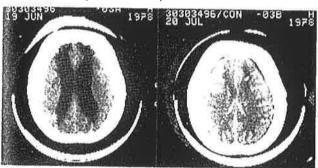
CT scan of the brain before and after the insertion of a ventriculoperitoneal shunt. Note the thick calvarium and the dilated ventricles (loft) before surgery. The patient was demonted before surgery, and improved considerably after insertion of the shunt.
